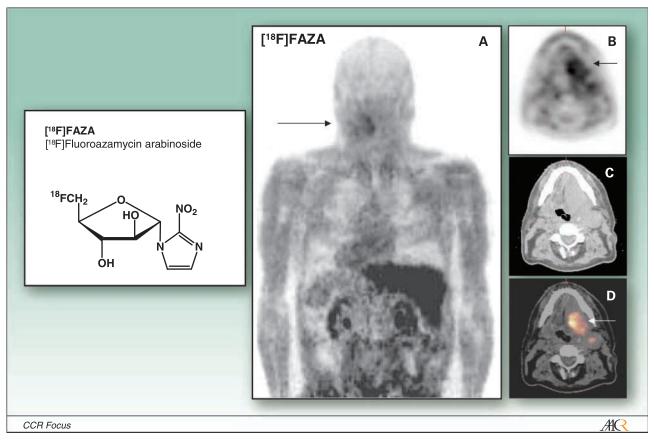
[18F]FAZA. Arrow, [18F]FAZA-PET/CT of a patient with a squamous cell carcinoma in the head and neck. [18F]FAZA accumulation indicates a hypoxic area in the tumor. *A*, maximum intensity projection of [18F]FAZA-PET. *B*, transaxial section of [18F]FAZA-PET. *C*, corresponding transaxial section of CT. *D*, fused image ([18F]FAZA-PET/CT).
